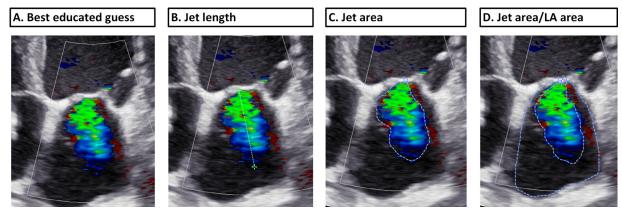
Different color Doppler grading approaches
